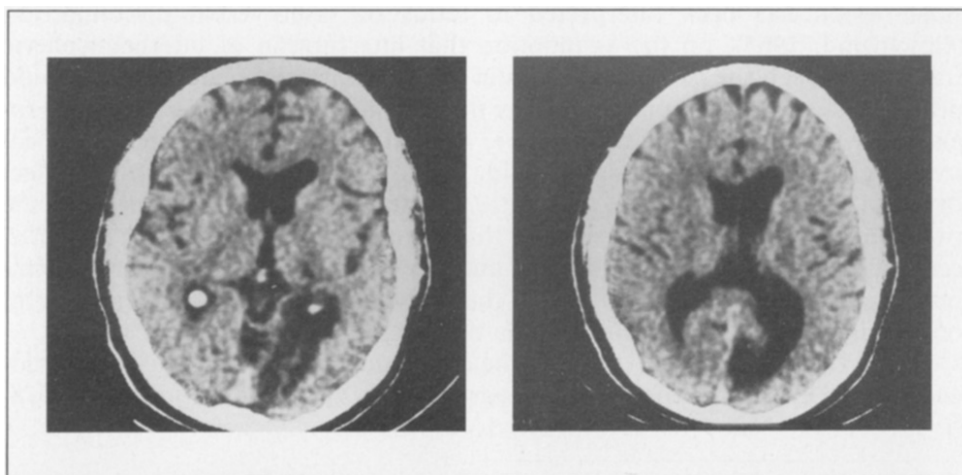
CT scan showing infarction in the territory of the left posterior cerebral artery.
